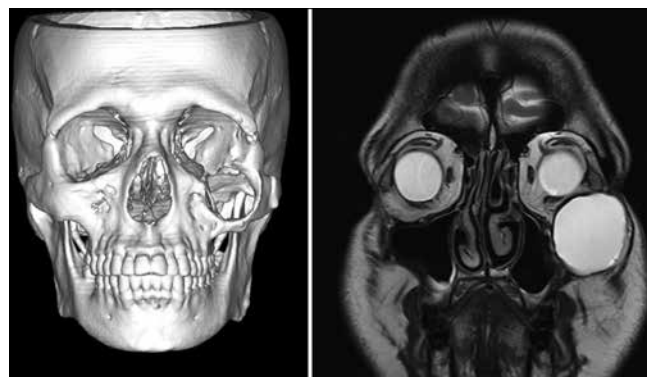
Pre operative CT scan and MRI
